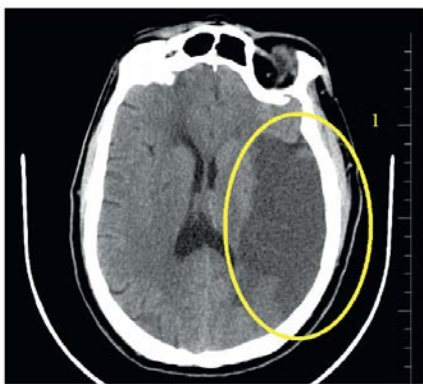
Multislice computed tomography of the brain on the following day after carotid endarterectomy: 1 — acute cerebrovascular accident of ischemic type in the left parietal-temporal region
